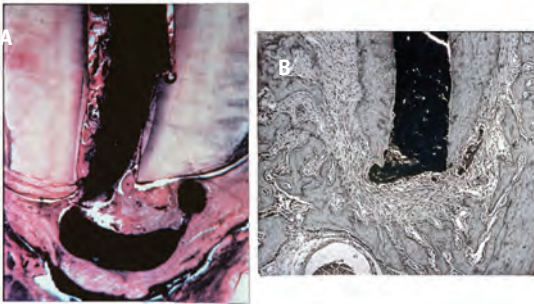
"Elimination of bacteria and bacterial plaque as well as complete obturation of the properly prepared canal. A, Incomplete obturation of an improperly prepared canal leads to apical inflammation and infection. B, Canal properly prepared and obturated leads to complete healing and a return of the normal periapical structures."
